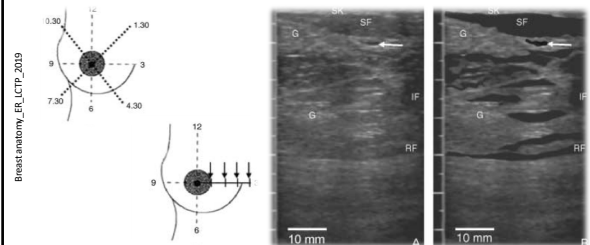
(A) Ultrasound image of tissues of the lactating breast.
